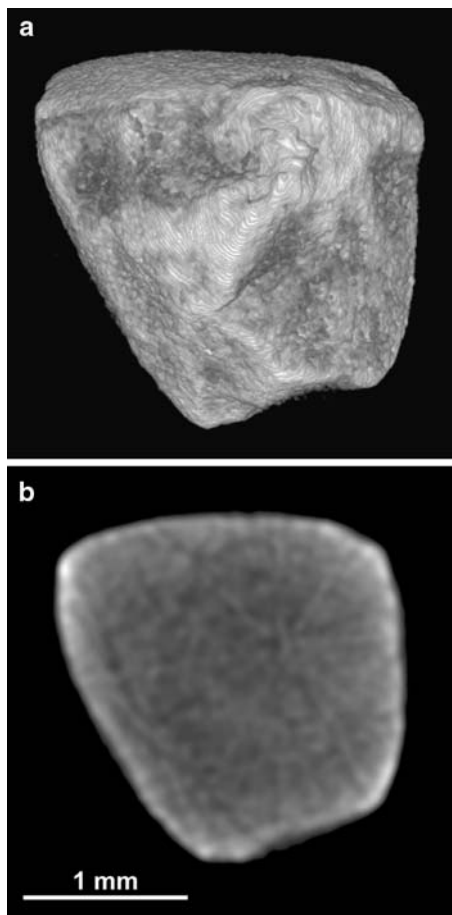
Fragment of COM stone that did not fall through 2 mm mesh even after 2,000 SW's. Shown is surface rendering of micro CT images (a) and slice through middle of stone (b). The radial shadows through the middle of the slice image are reconstruction artifact, and the brightness at the edge of the stone is due to beam hardening artifact. Careful examination of the serial slices showed no evidence of content other than COM in this fragment
